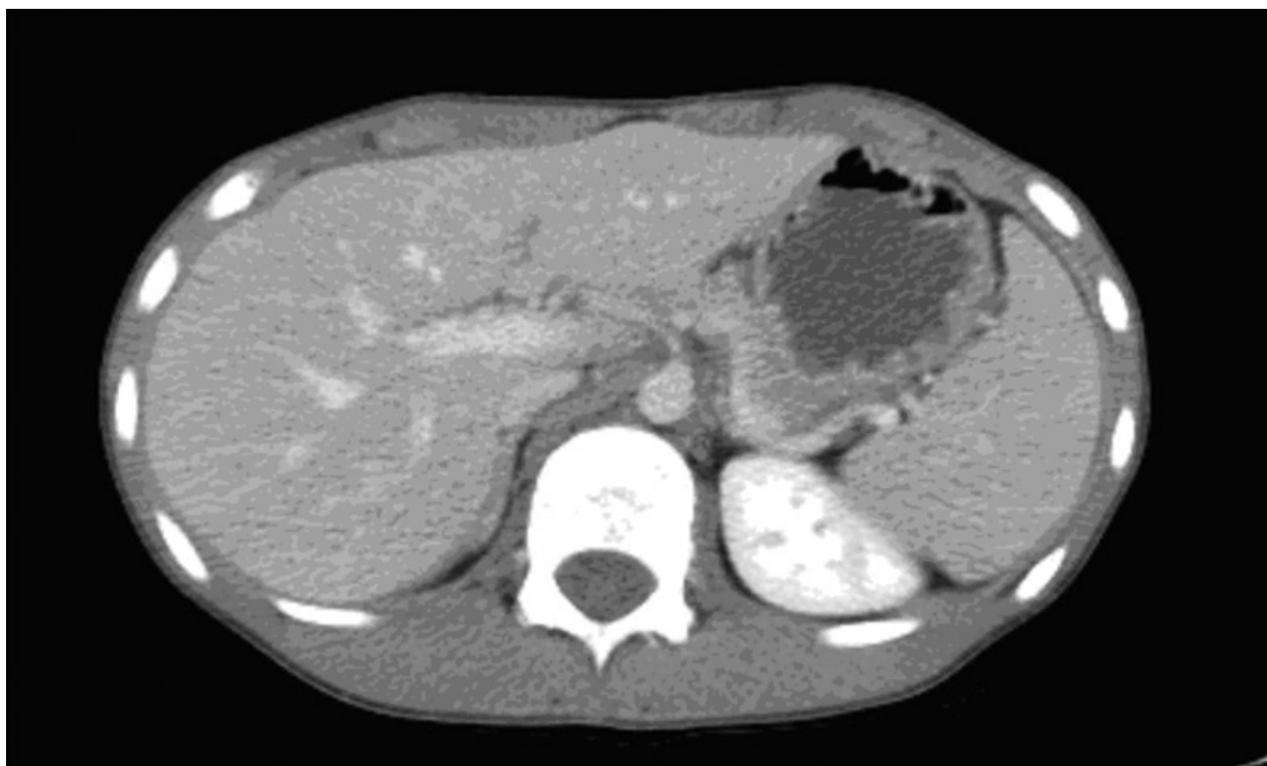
CT imaging of duodenal haematoma.
